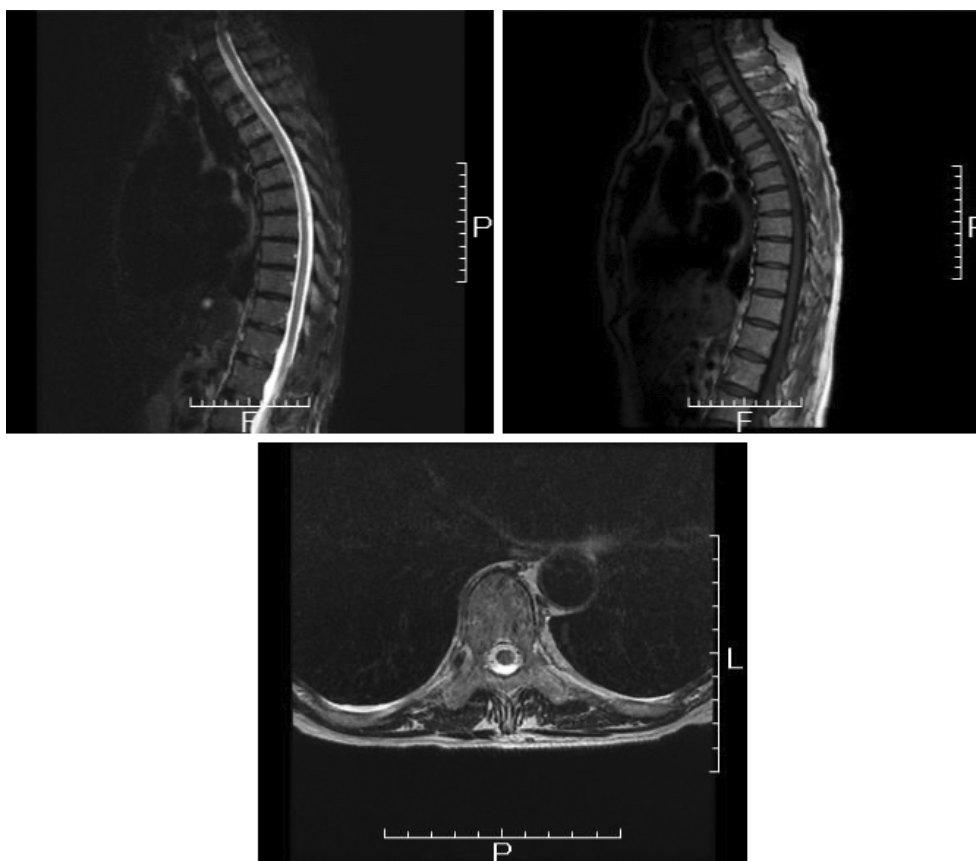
MRI scans of the spinal cord on postoperative day 10 after the second operation
